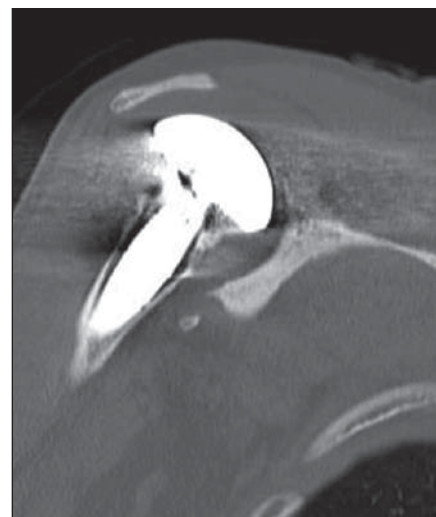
Subluxation axillary radiograph in 47-year-old man with shoulder hemiarthroplasty for degenerative arthritis shows moderate posterior subluxation (25–50% translation of humeral head).
